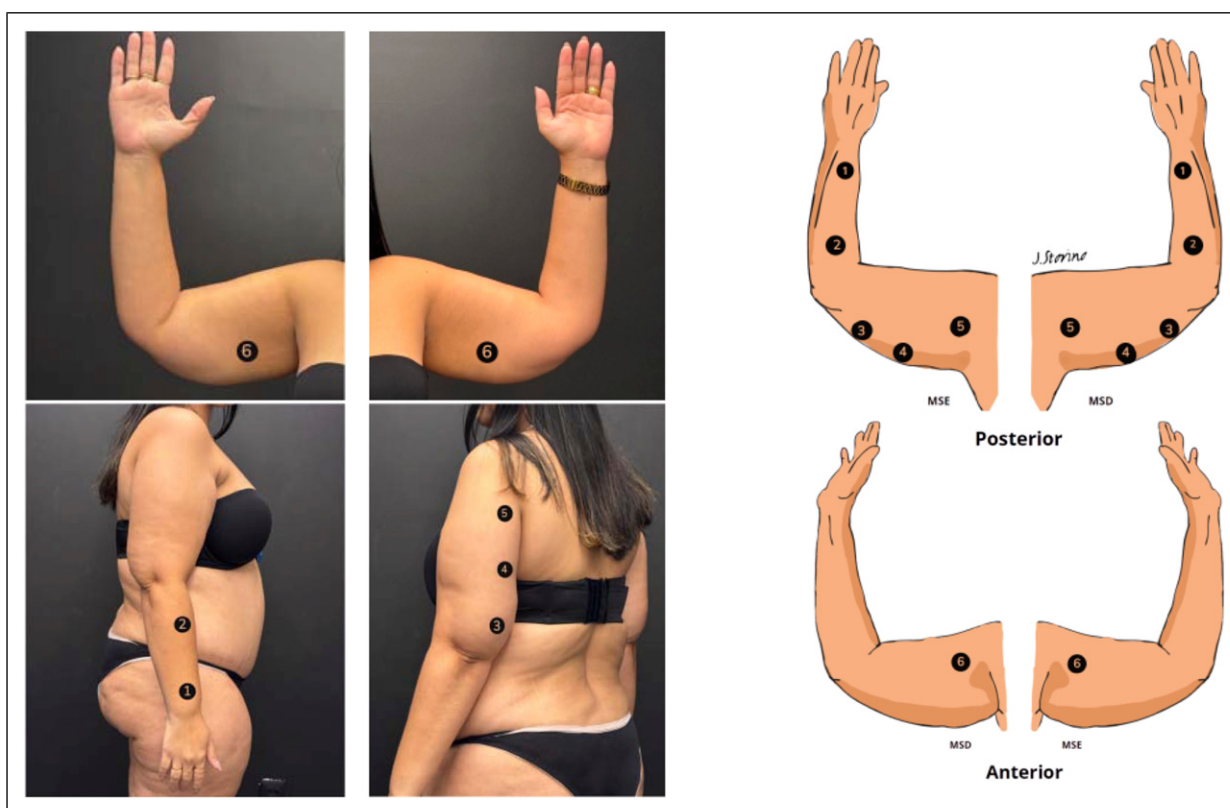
Ultrasound measurement points: P1 dorsal forearm (6 cm proximal ulnar styloid); P2 dorsal forearm (6 cm distal elbow); P3 posterior arm (10 cm proximal olecranon); P4 posterior mid-arm (10 cm distal posterior axillary line); P5 posterior arm (6 cm distal posterior axillary line); P6 anterior arm (6 cm distal anterior axillary line).
